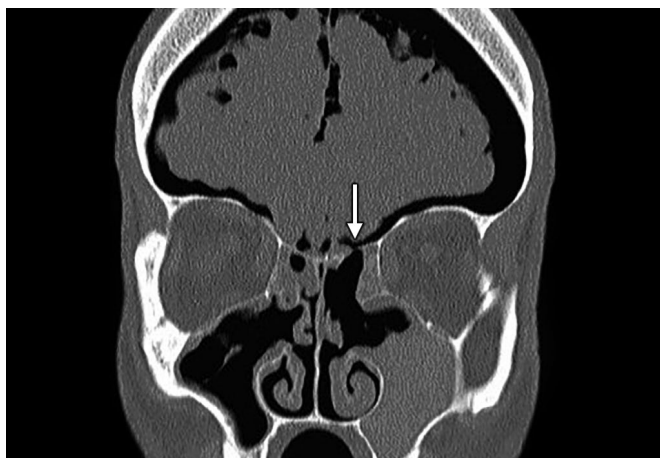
Noncontrast coronal CT sinus in a patient who presented to the emergency room with severe headaches 1 day following endoscopic sinus surgery. There was no clinical evidence of cerebrospinal fluid (CSF) rhinorrhea or mental status changes. However, a defect in the left fovea ethmoidalis (arrow) and extensive pneumocephalus was noted. Intraoperatively, a bony defect with no evidence of dural tear or CSF leak was noted.
